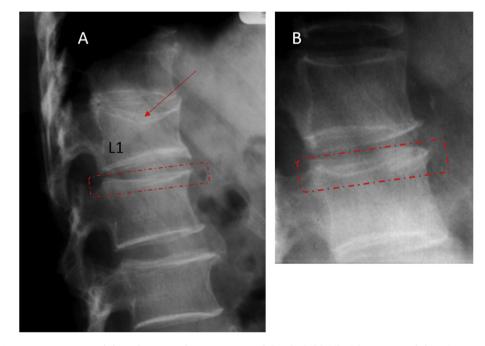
(A) L1 upper concave endplate fracture (long arrow) and Grade 2 SQ-VD. L2 upper endplate is normal (dotted square) which may be misdiagnosed as endplate fracture. This is due to the projection of endplate ring; note the parallel multilayered endplate lines and that there is no depression; (B) Radiograph from another subject demonstrates a similar appearance of upper endplate (without fracture).
